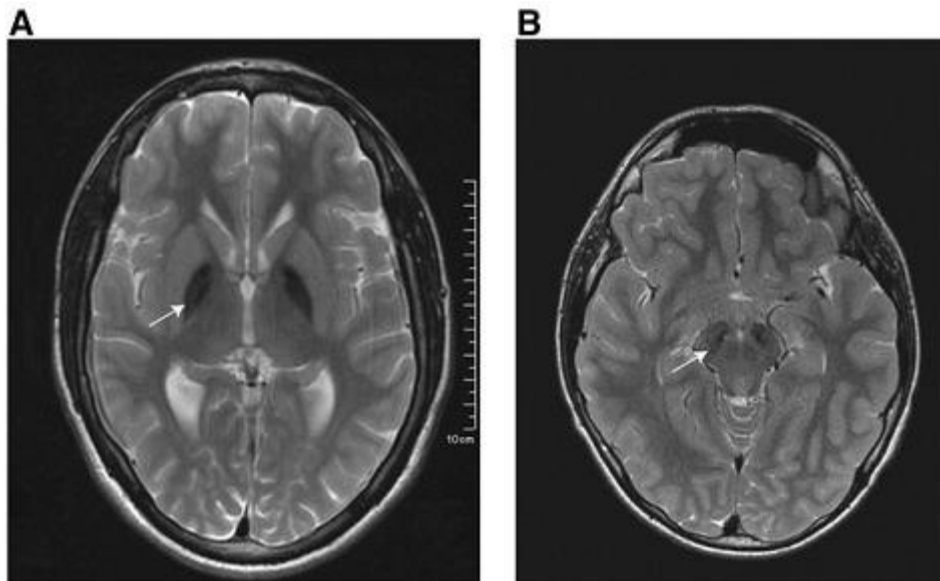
Axial T2-weighted MRI of individuals with MPAN
